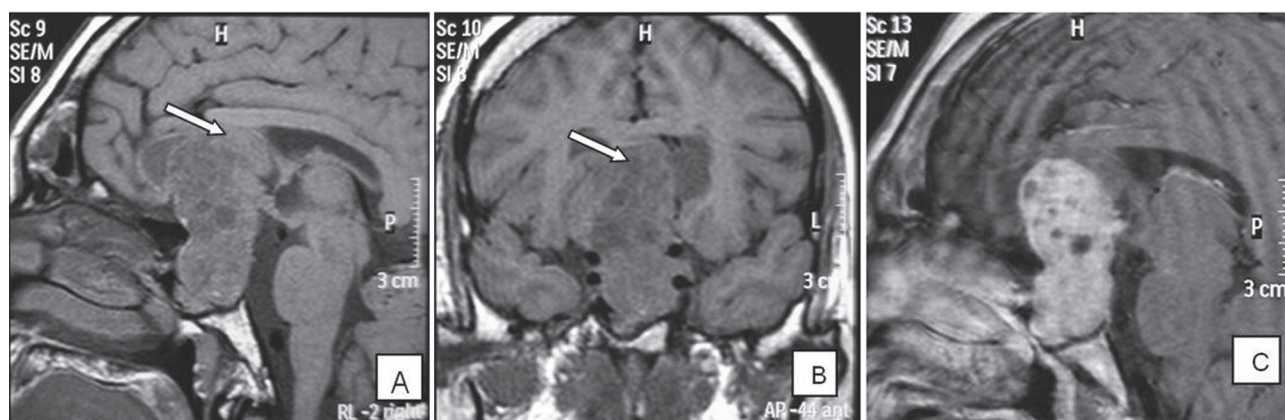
A-B. Pituitary sagittal and coronal T1-weighted MRI scan, respectively. C. Pituitary sagittal T1-weighted MRI scan after gadolinium enhancement. The pre-treatment MRI figures depicted a giant macroadenoma of 6 cm in craniocaudal diameter, with diffuse inhomogeneous enhancement after gadolinium administration, occupying the sella turcica and eroding the sella and the clivus. The tumor had suprasellar extension compressing the optic chiasm as well as the third ventricle and the frontal horns of the lateral ventricles (arrows) and infrasellar extension invading the sphenoid and cavernous sinuses. Encapsulated cerebrospinal fluid was also present around the upper edge of the lesion.
